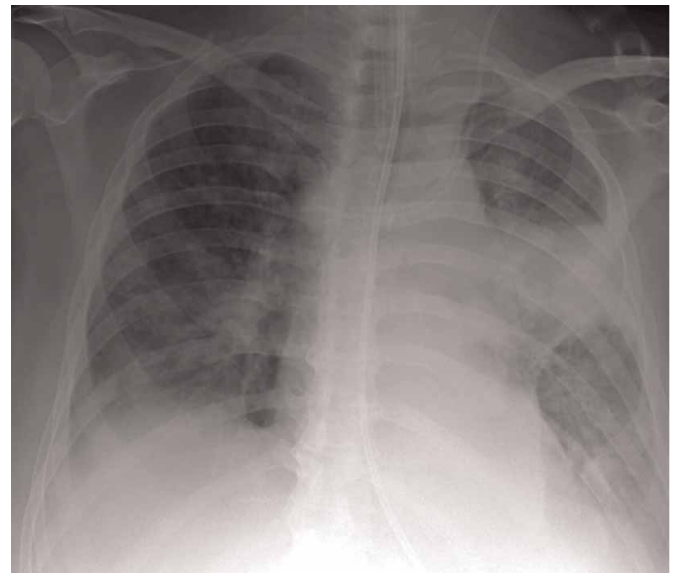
Chest radiograph revealing a mass in the left lung middle zone.
